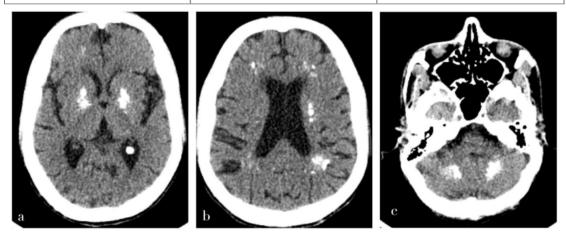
Cranial axial CT brain showing bilateral symmetrical dense radial and punctate calcifications involving bilateral cerebral (Fig.1a,1b) and cerebellar hemispheres(Fig.1c).
